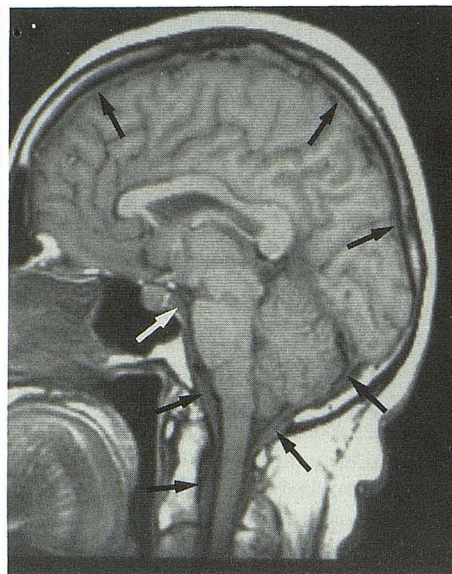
Sagittal T1-weighted (400/20) MR image shows diffuse thickening of dura and meninges (arrows) extending to preptine cistern, craniovertebral junction, and cervical region.
